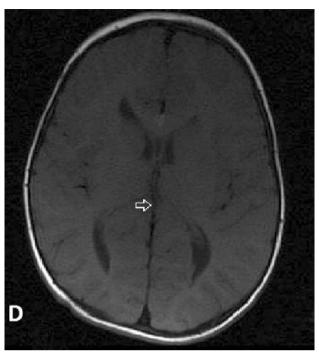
(A-D): Sagittal and parasagittal CT sections showing falxcerbri calcification (white arrow in A), nasal dermoid (black arrow in B) and left parasellardermoid (D).Contagious axial T1W MRI images showing peri-callosal lipoma & callosal dysgenesis (arrows in Fig. C & D).
